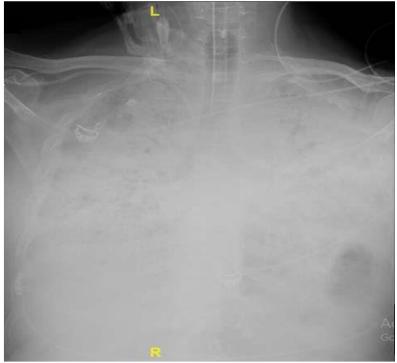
Chest radiography with fibrosis on intensive care unit day four
